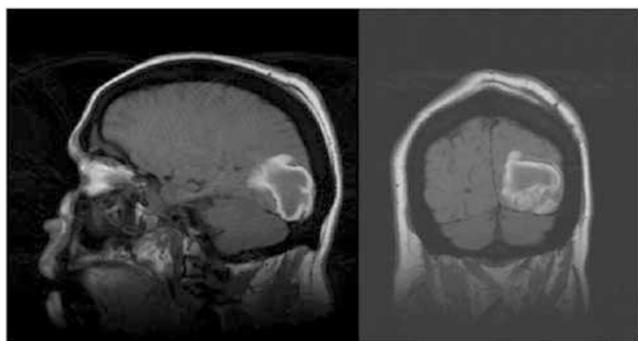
MRI of the brain with hemorrhagic lesion in the left occipital area
